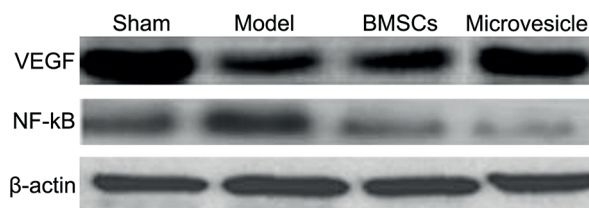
Effects on VEGF and NF-κB protein expression by the facilitation of BMSCs homing from ultrasound microvesicle.
